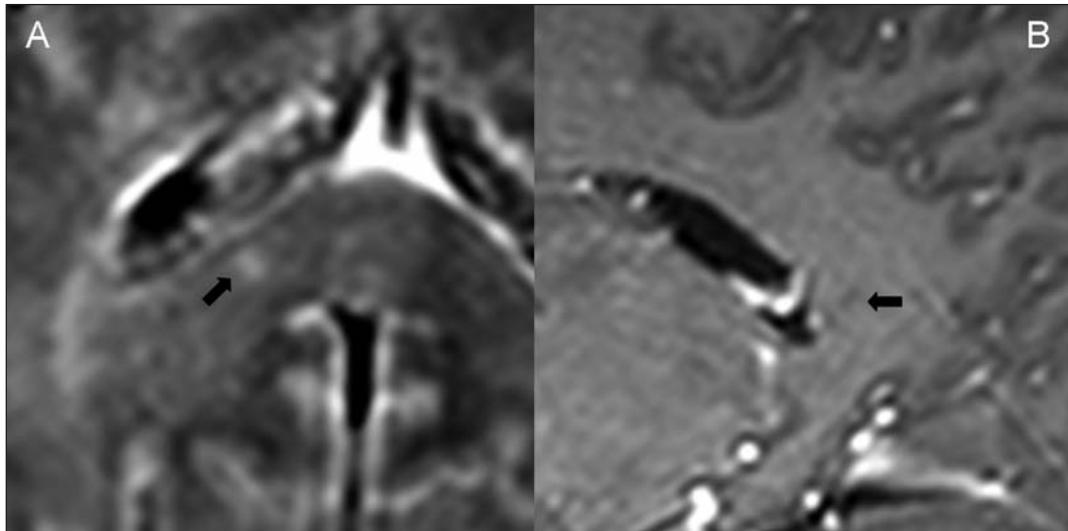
Axial FLAIR image (A) and sagittal T1 post gadolinium image (B) demonstrating a corpus callosum lesion involving the central fibers (A and B, arrow).
